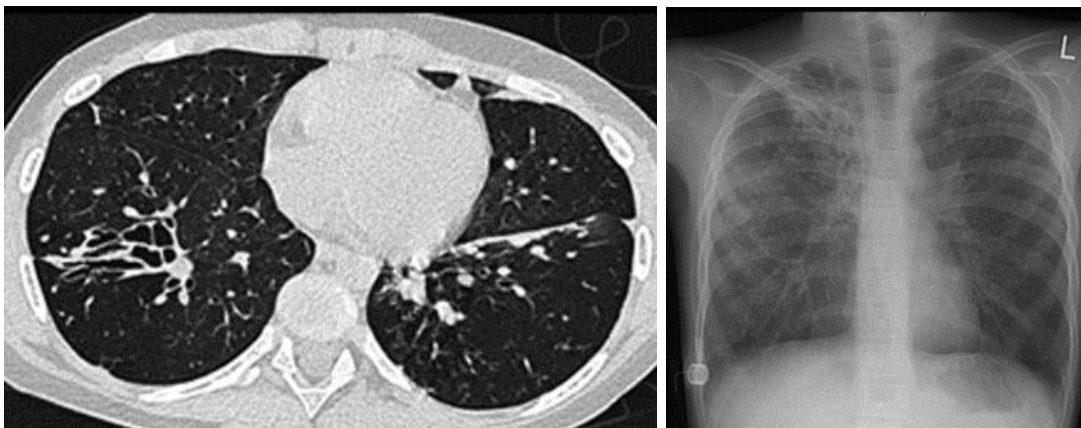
Severe bronchiectasis in a patients with end-stage cystic fibrosis (CF) shown in both chest radiograph (left) and computed tomogram (right) images. For reasons that are not fully understood, the upper lobes are often most severely affected in CF, although this patient has severe bronchiectasis throughout the whole of the right lung. Note the presence of indwelling intravenous catheter (a “port-a-cath”) on the right lateral chest wall. Images taken from Davies *et al.* (2007) with permission.
